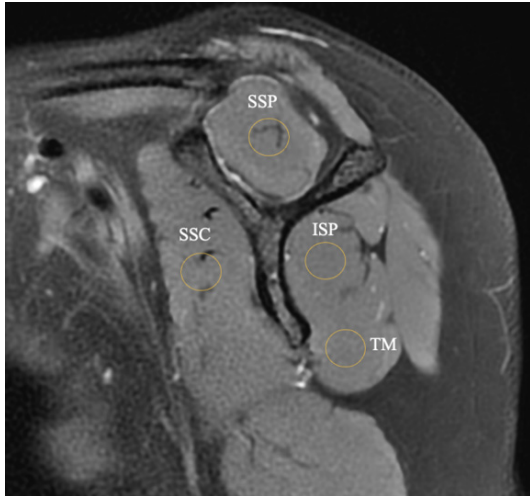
Oblique sagittal fat suppression T2-weighted MRI images, respectively, and ROI (35-40 mm²) were selected at the same level for all subjects, and these are circled in yellow. The FA and ADC values of the muscles corresponding to ROI were measured.
